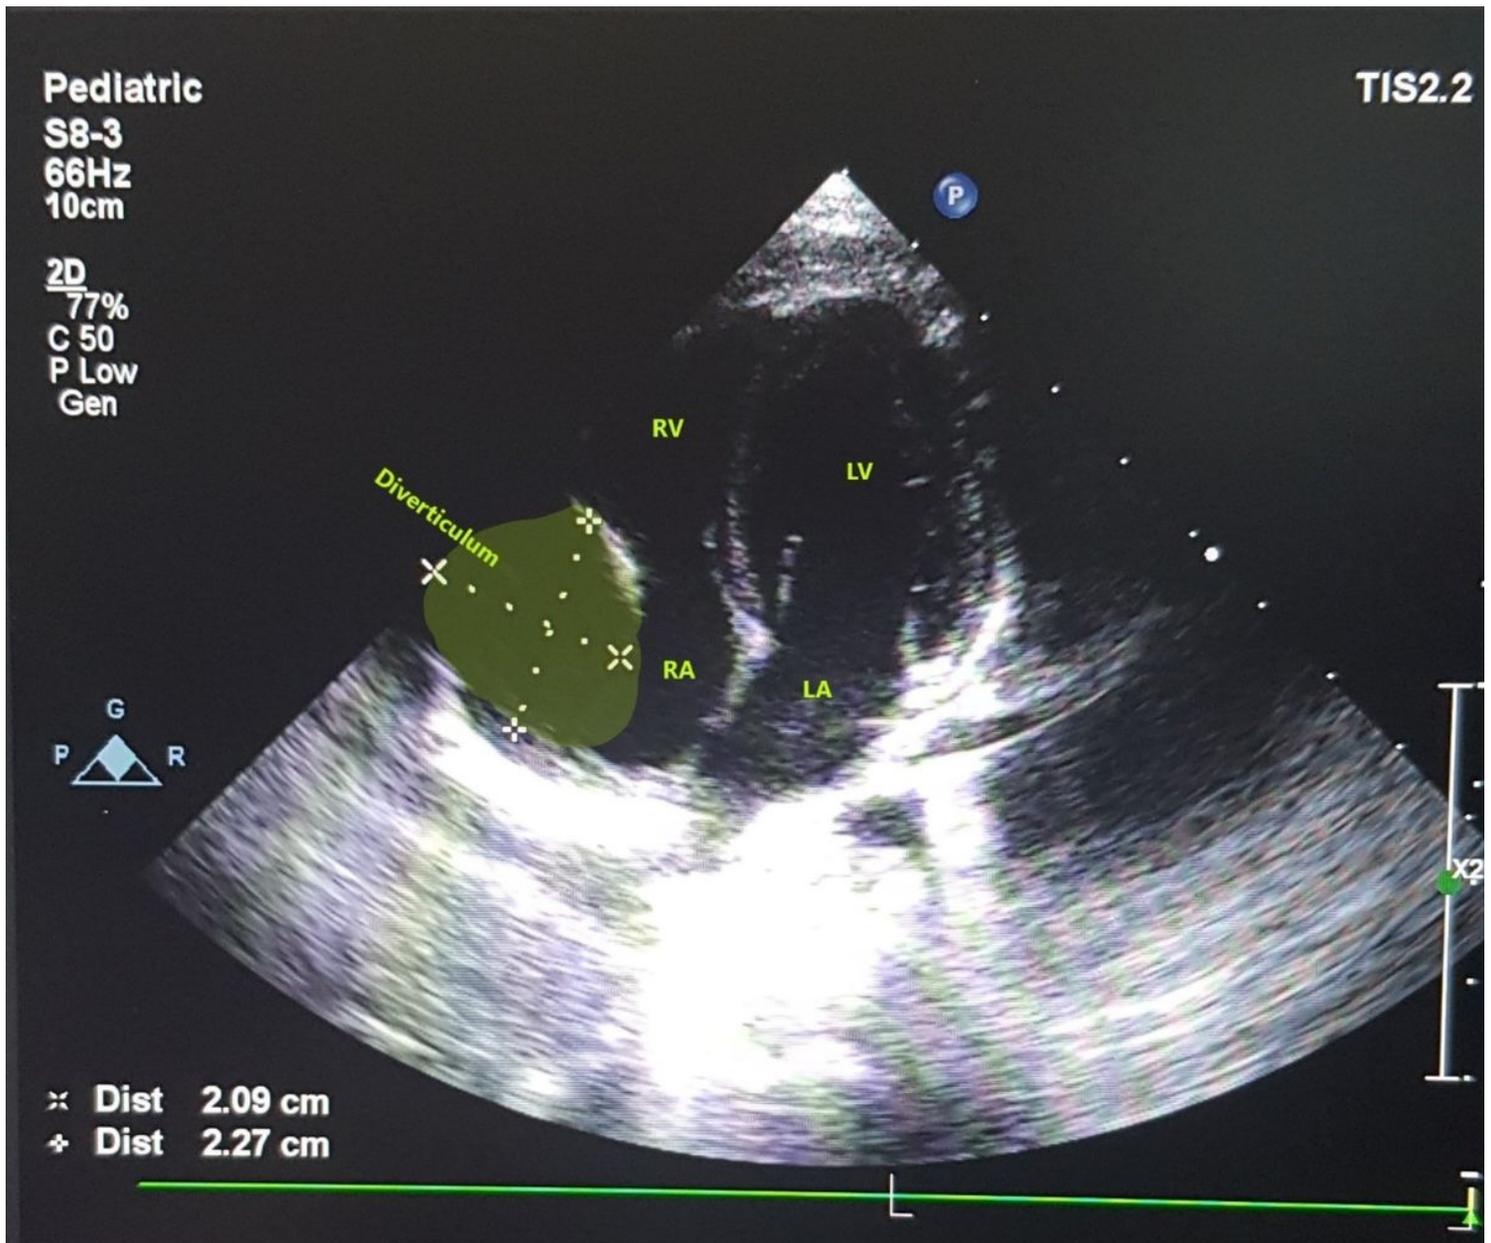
echocardiography of the 3 days old neonate's heart showed a diverticulum measuring 2.09*2.27 attached to the lateral wall of the right atrium.
